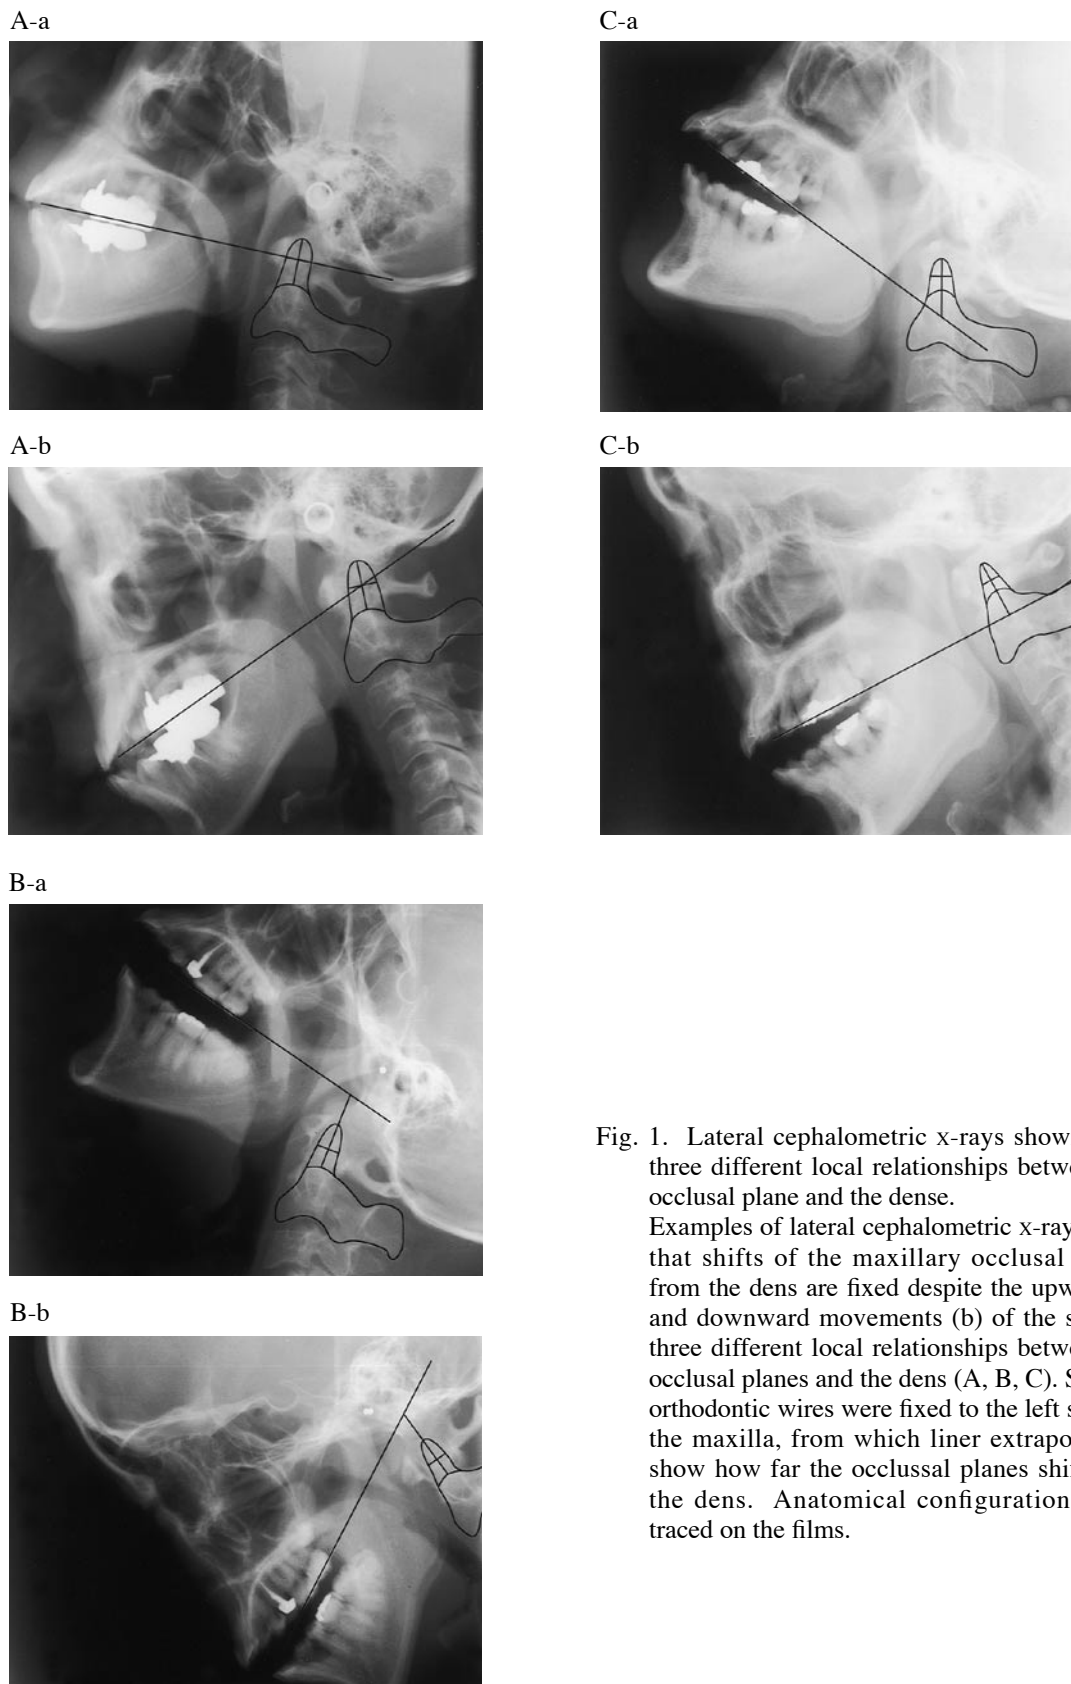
Lateral cephalometric x-rays showing the three different local relationships between the occlusal plane and the dens.
